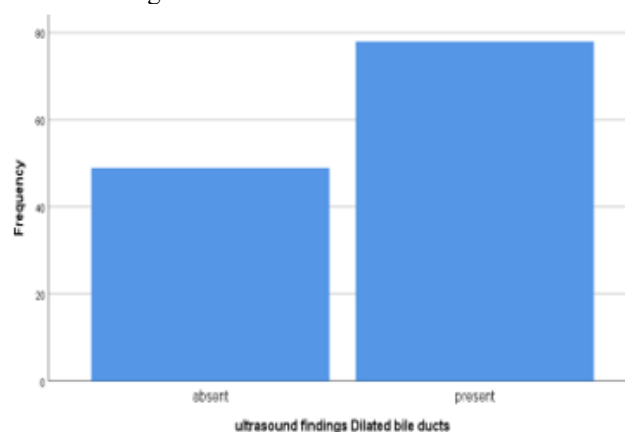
Ultrasound detection of dilated bile ducts
